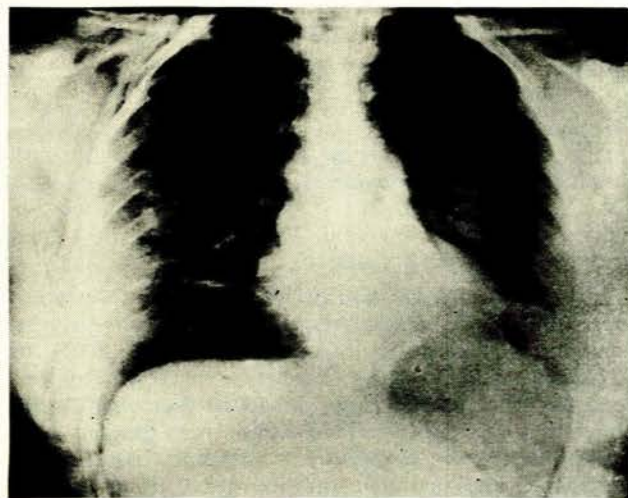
Chest X-ray of case 3.
